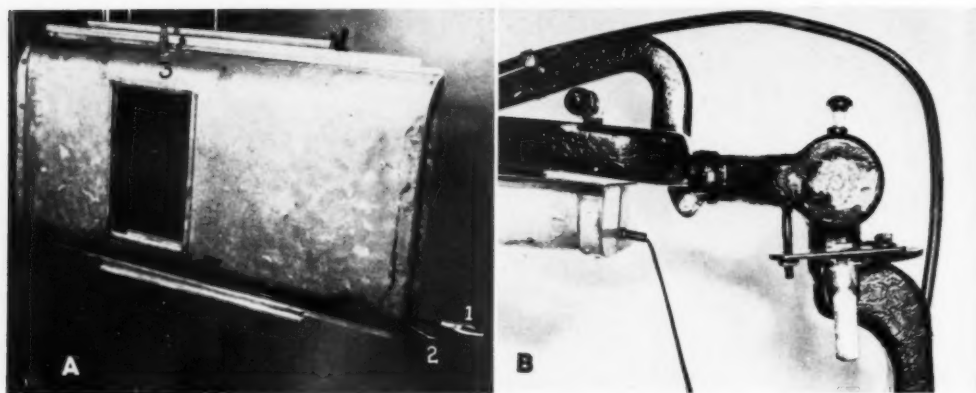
A. Spot film device used in myelography and gastro-intestinal examinations, showing one half of 8×10 -inch cassette ready for exposure. 1. Bar with ring used to return cassette to fluoroscopic position and close fluoroscopic switch setting. 2. Trip lever used to throw half of cassette in radiographic position and close radiographic switch. 3. Lever to throw second half of cassette in radiographic position. B. Adjustable bracket to support fluoroscopic arm. Threaded bolt permits varying height of spot-film device for patients of different thickness.
